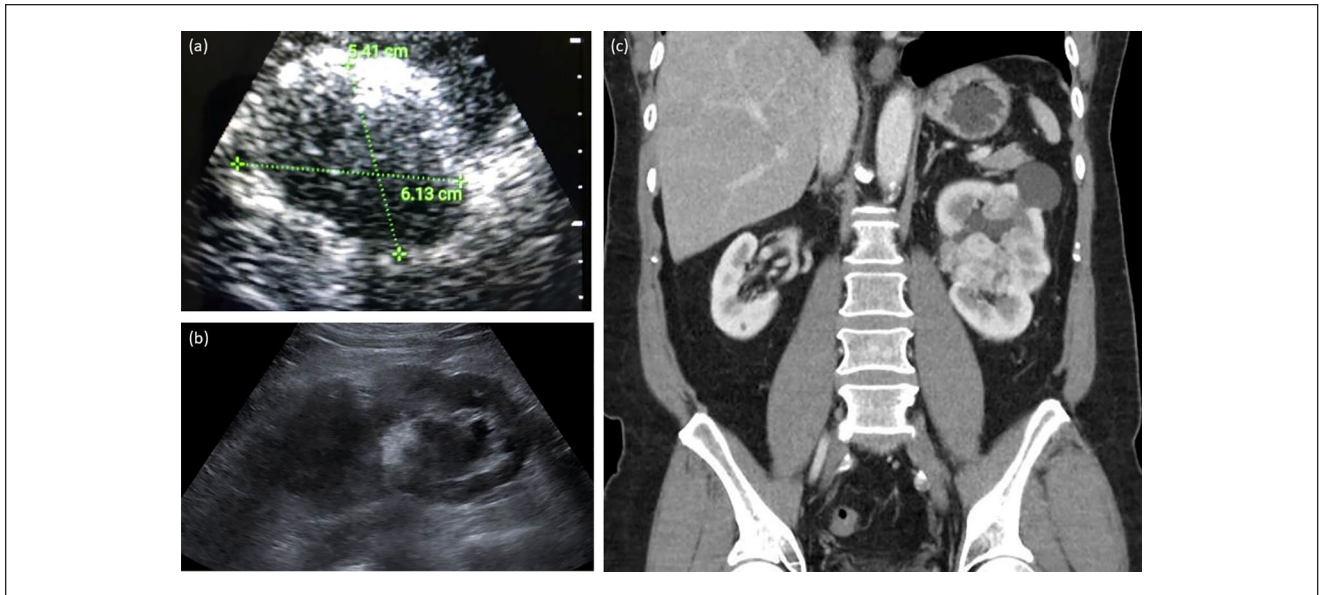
(a) Point-of-care ultrasound image of the left kidney in an asymptomatic 63-year-old man shows a large isoechoic solid mass measuring approximately 6 cm in its largest dimension. (b) Formal renal ultrasonography image of the left kidney showing distortion of normal renal architecture with a centrally located heterogeneous solid mass. (c) Contrast-enhanced computed tomography imaging of the abdomen and pelvis, coronal view shows an 8 cm × 5.5 cm × 8 cm heterogeneously enhancing mass consistent with renal cell carcinoma in the left kidney, as well as a simple renal cyst in the superior pole of the left kidney. Three months after these images were obtained, the patient developed gross hematuria.
